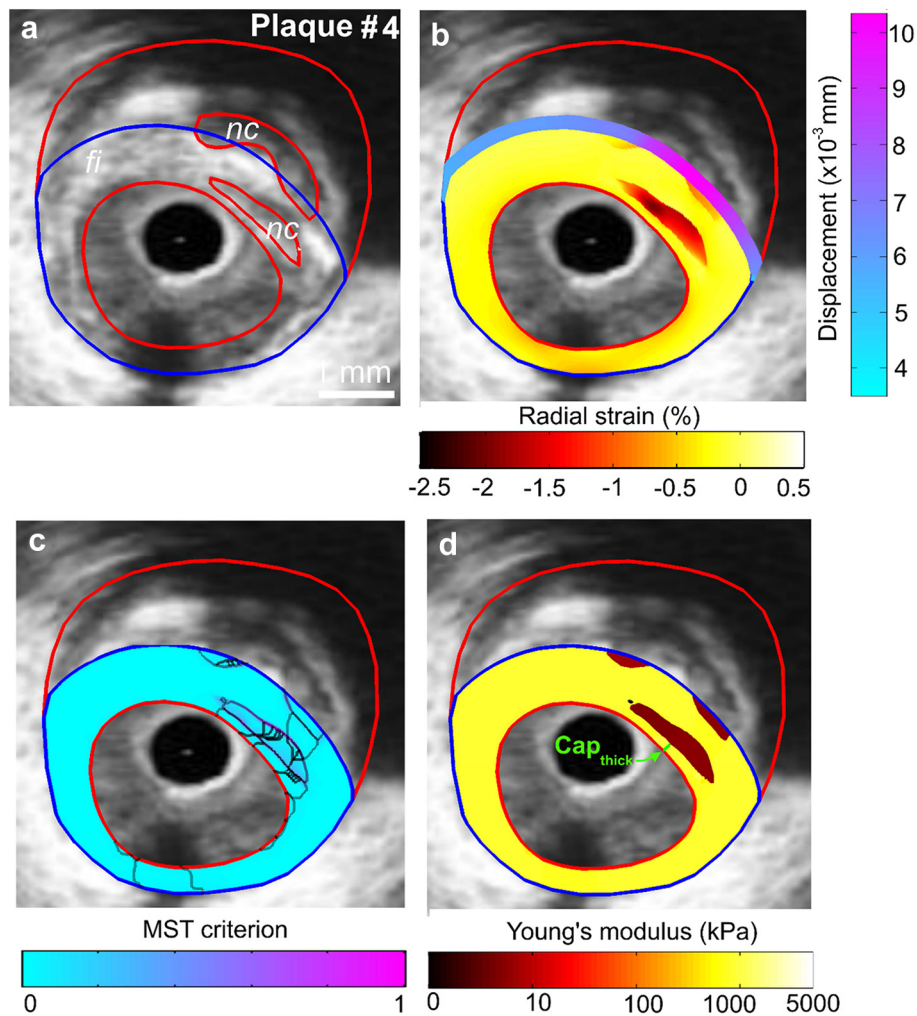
Performance of the E-iMOD technique to detect a vulnerable plaque with two distant necrotic cores. (a) Intra-vascular ultrasound image of plaque #4 with plaque constituents (*red contours*). (b) Radial strain- elastogram and displacement applied on the intraplaque outer endoluminal boundary. (c) Spatial distribution of the normalized MST criterion and extracted inclusions contours ($n = 40$). (d) Computed modulogram. nc = necrotic core; fi = fibrous region.
